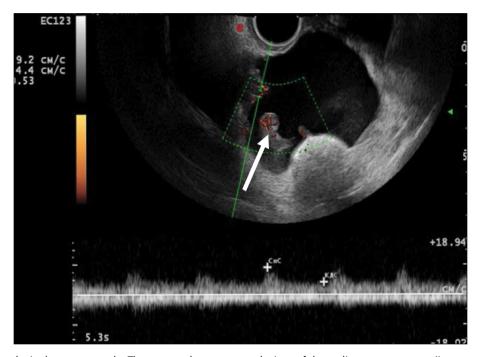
Dopplerography in the energy mode. The arrows show recurrent lesions of the malignant struma ovarii.
